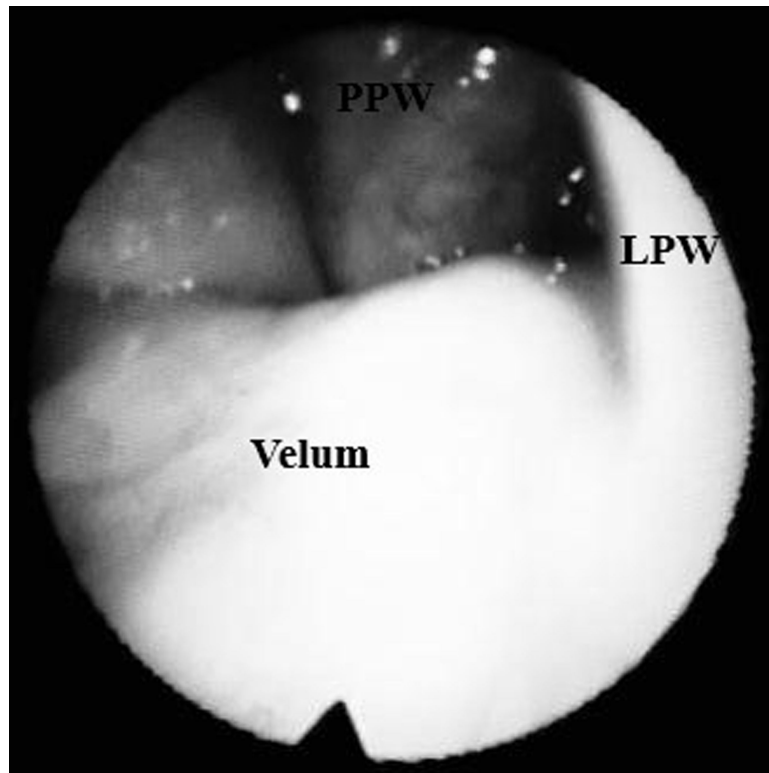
Asymmetrical VP closure. Nasopharyngoscopy displaying the asymmetrical VP closure. However, magnetic resonance imaging of this participant (Figure 1) displays minimal asymmetry between the right and left length of the levator muscle bundles. Abbreviation: LPW indicates lateral pharyngeal wall; PPW, posterior pharyngeal wall.
